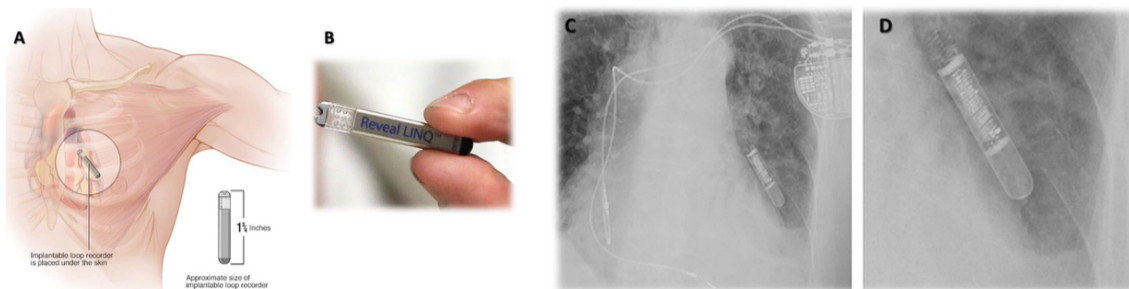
The implantable loop recorder is a small subcutaneous device implanted under the skin of the chest for up to three years (A, B). Chest radiographs (PA projections) of an implanted loop recorder (C,D): note the dimension comparison with a modern implanted dual-chamber pacemaker.
